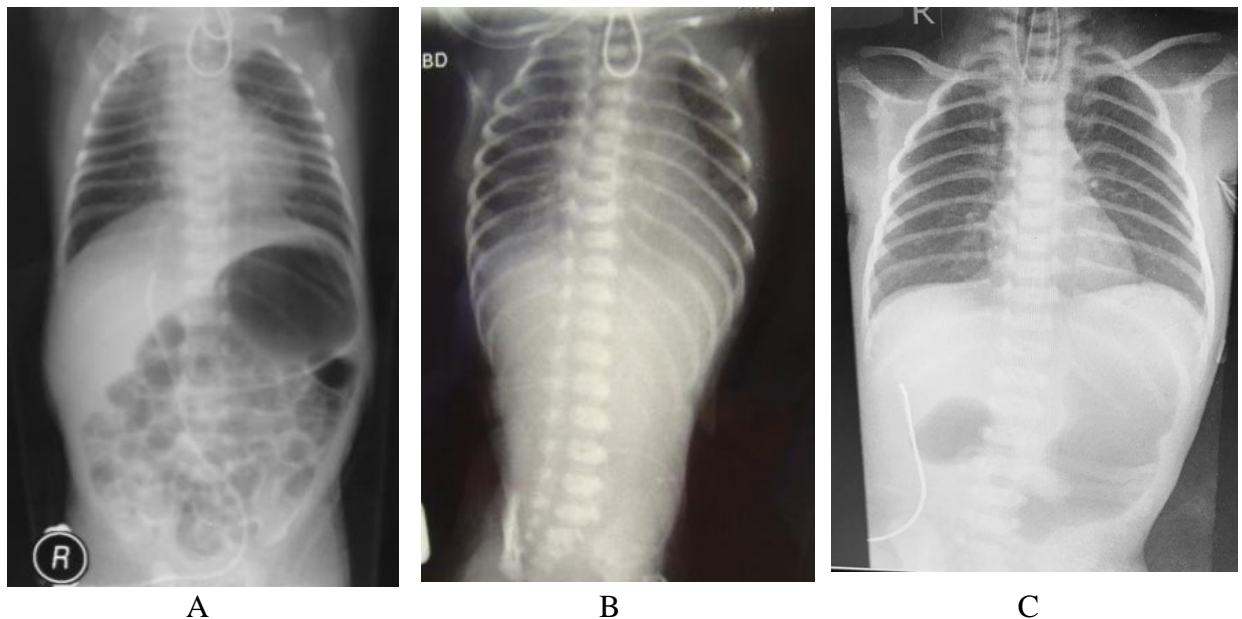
A - Chest X-ray in a neonate with EA and distal TEF. The tube is coiled in the blind-ending upper esophagus. Air outlining intestinal loops below the diaphragm confirms the existence of a distal TEF. B - “Pure” EA. The nasogastric tube is coiled in the upper esophageal pouch. Absence of air-filled abdominal intestinal loops suggests that there is no distal TEF. C - EA and TEF with duodenal atresia. Nasogastric tube coiled in upper pouch. ‘Double-bubble’ appearance confirms duodenal atresia
